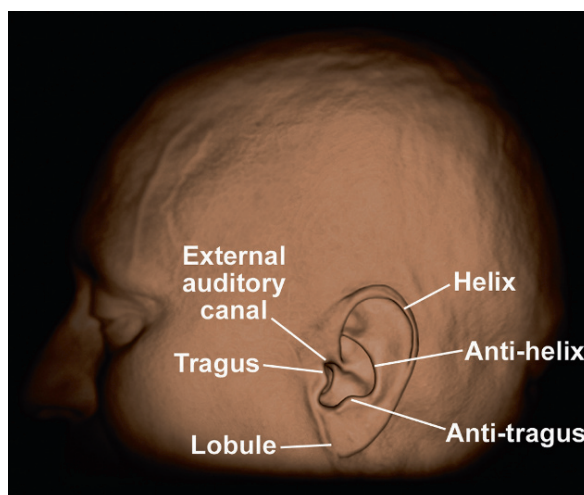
External ear. 3D skin surface reconstruction of the multi-detector CT (MDCT) dataset. Note anatomical landmarks of the external ear (pinna) and external auditory canal
